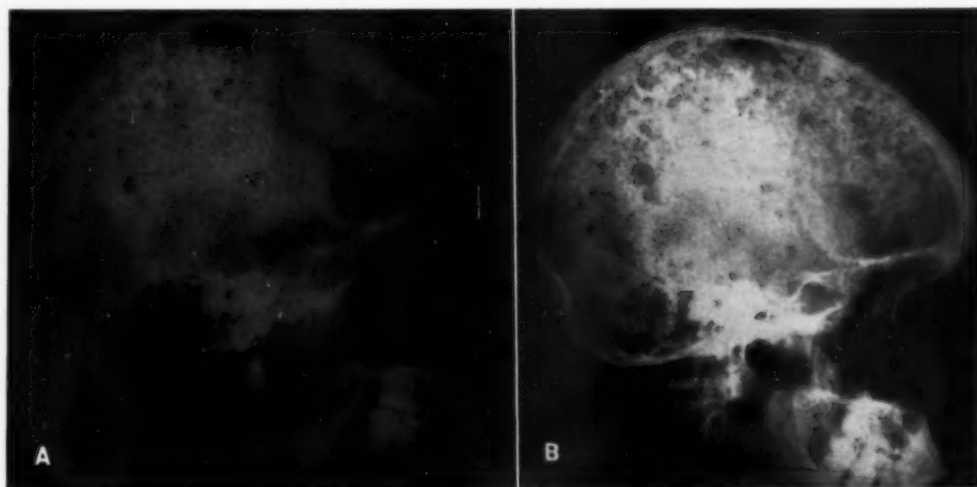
Lateral films of the skull. A. Roentgenogram taken on June 22, 1954, showing numerous, discrete, rounded and oval lesions of the skull, primarily involving the frontal and parietal bones. The sharpness of the outlines of these lesions is similar to that frequently seen in multiple myeloma. B. Roentgenogram taken on July 21, 1954, showing marked progression of the destructive bone lesions.
